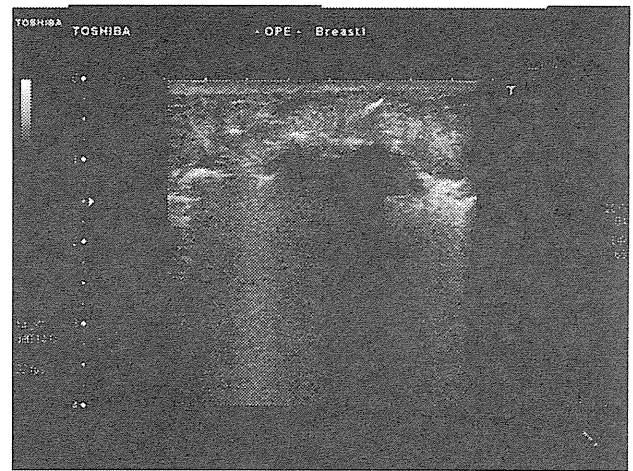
Intraoperative breast ultrasound. Radiofrequency was applied until the tumor was completely hyperechoic
